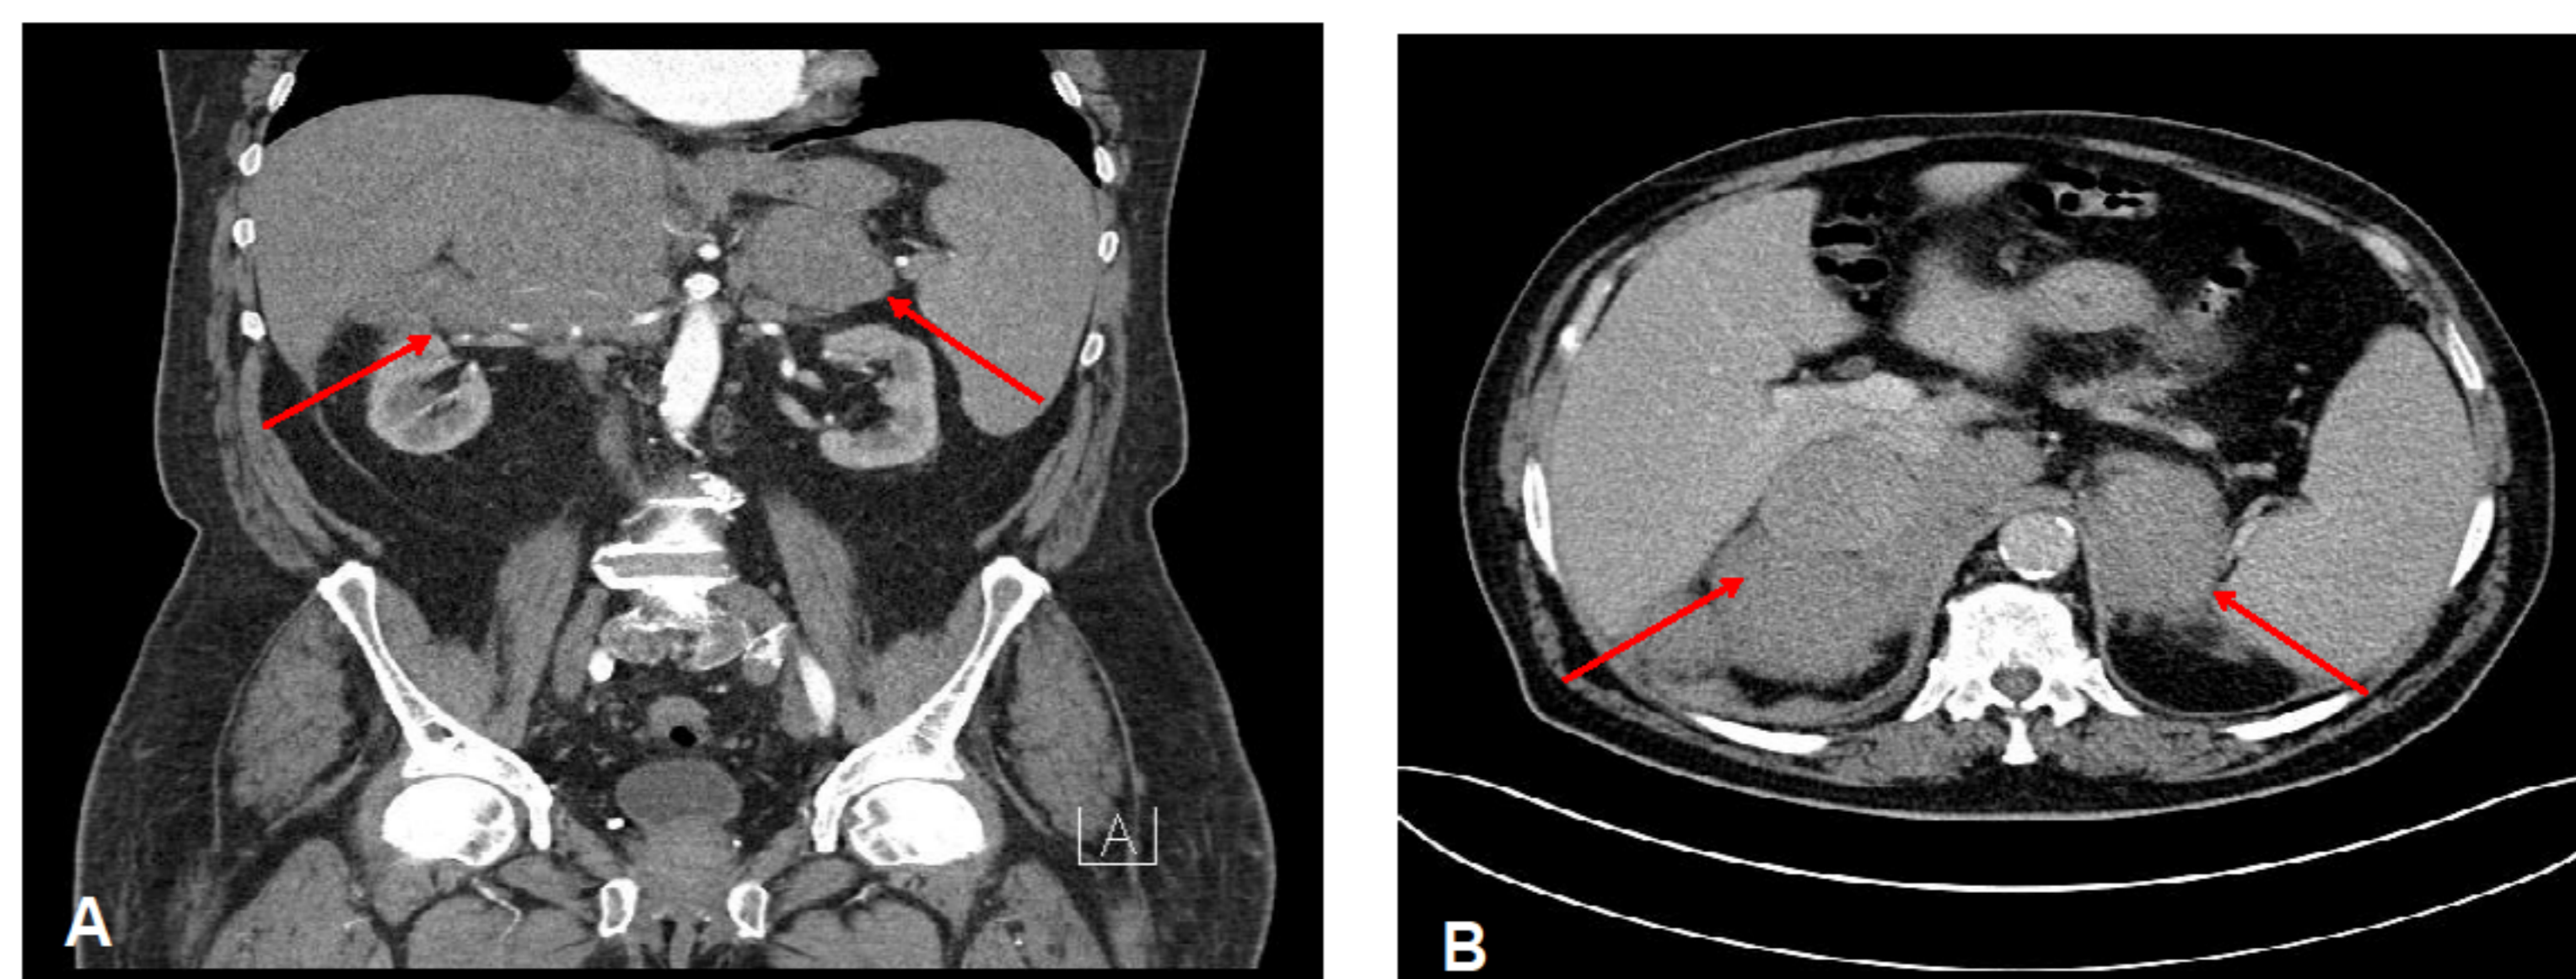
Abdominal CT scan: showed large bilateral adrenal masses . A: frontal section, B: transversal section
